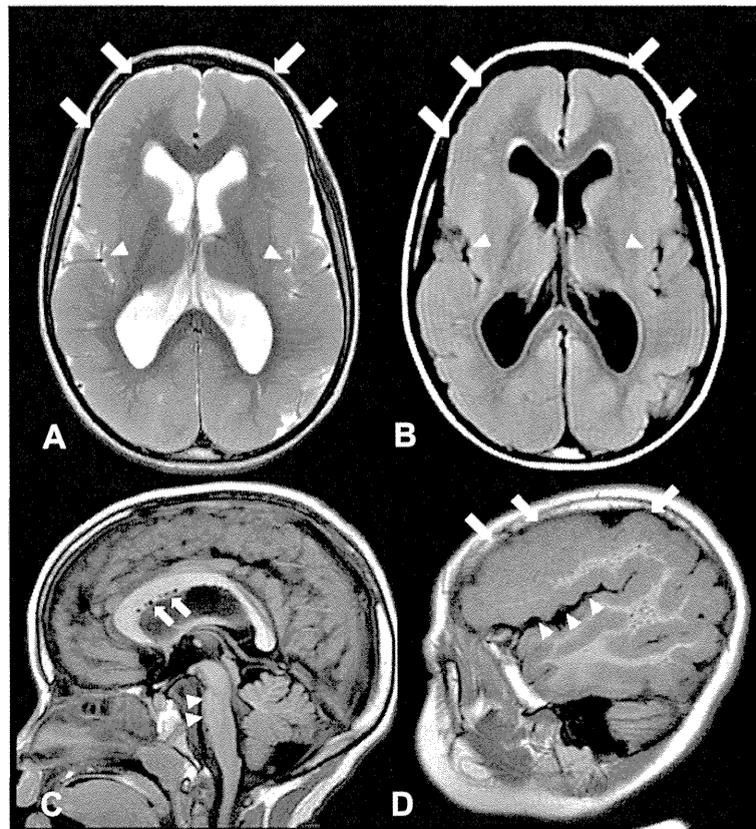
Neuroimaging. Axial T2WI (A) and FLAIR (B) images demonstrate bilaterally symmetric thick cortex and irregular gyri compatible to polymicrogyria with anterior to posterior gradient (arrows) and, patchy high signals on both T2WI and FLAIR in the frontal subcortical white matter. Note the less involved insular cortex (arrow heads). Sagittal T1WI (C) shows flat pontine basis (arrow heads) and small cystic lesions in the corpus callosum (arrows). Sagittal T1WI (D) shows bilateral polymicrogyria with anterior to posterior gradient (arrows), in contrast with relatively spared perisylvian region (arrow heads).
